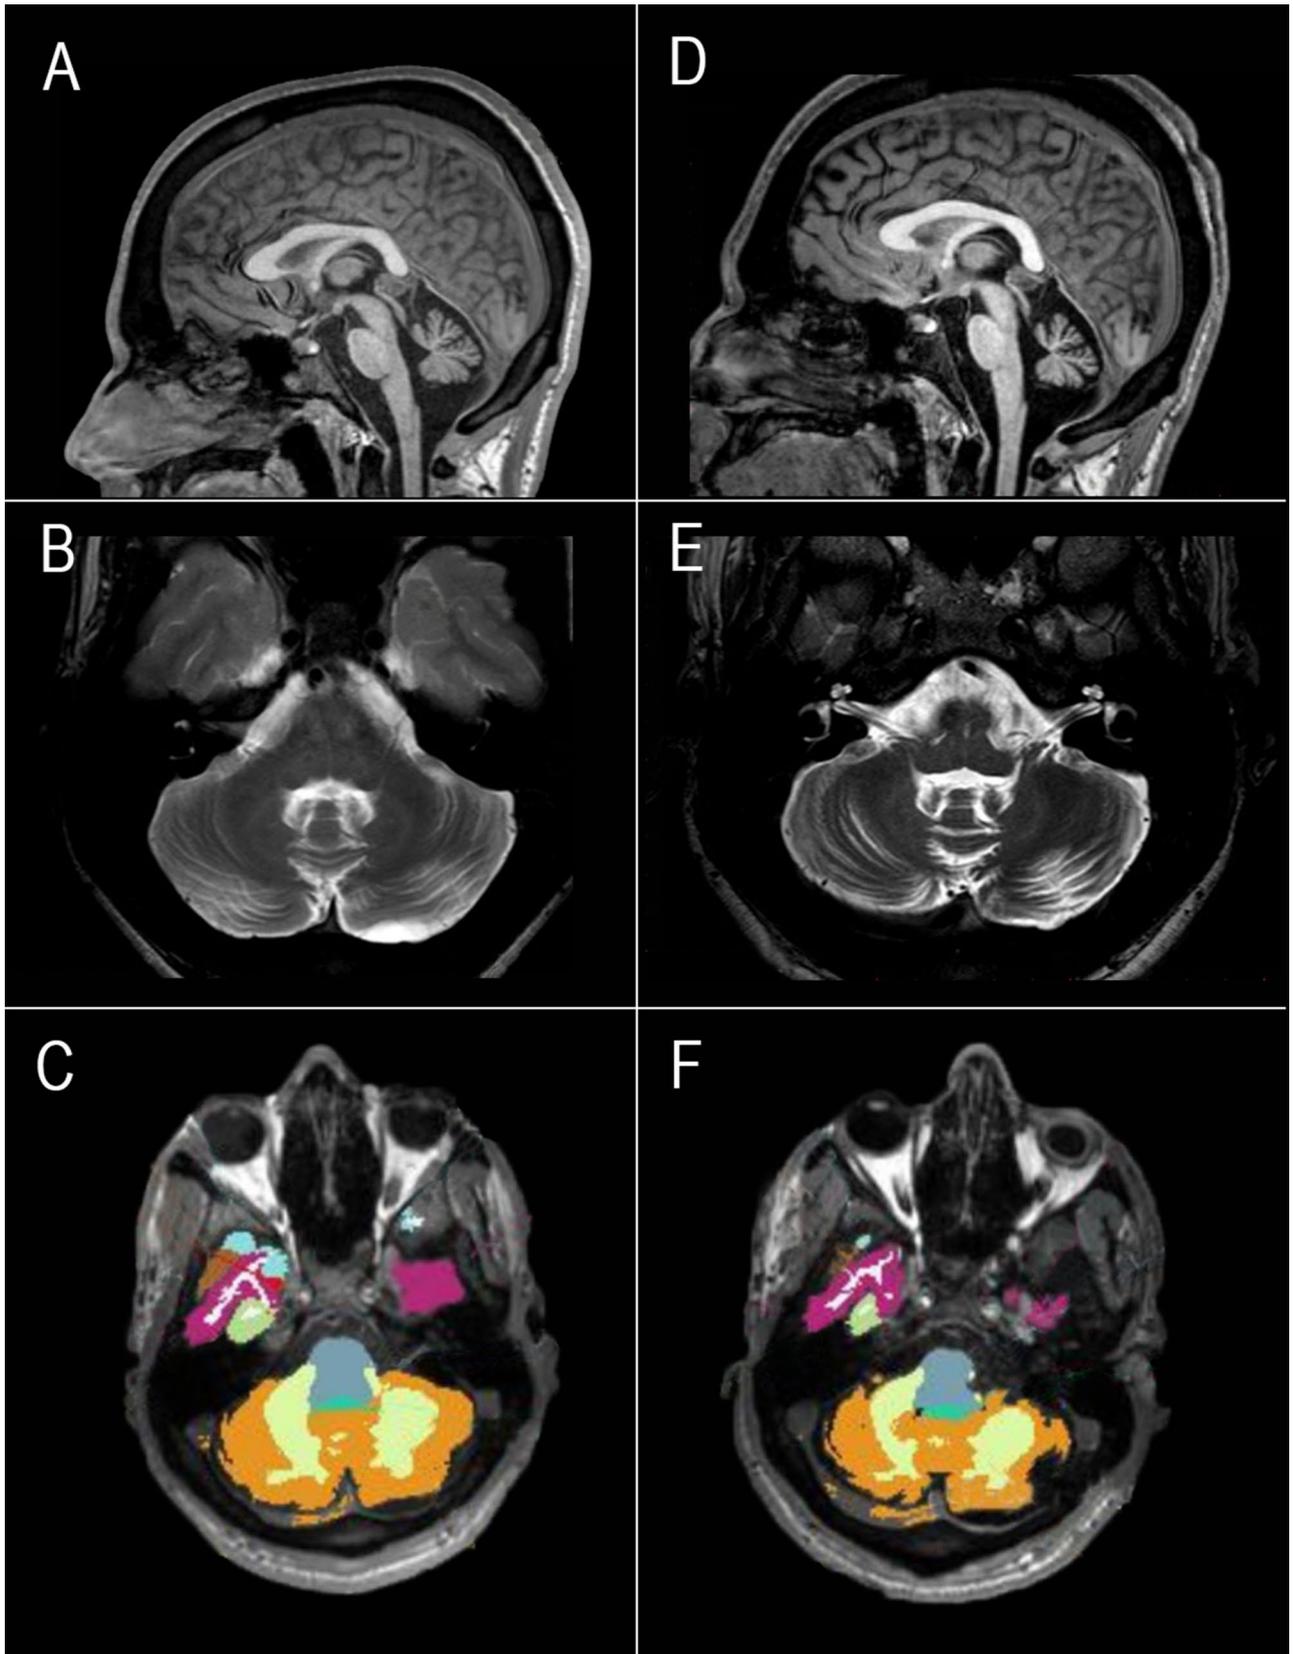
Brain MRI performed at the ages of 15 (A, B, and C) and 18 (D, E, and F). Sagittal FLAIR and axial T2-weighted sequences revealed marked cerebellar atrophy with mild pontine atrophy. Segmentation is projected onto an axial slice of the cerebellum at the ages of 15 (C) and 18 (F)
